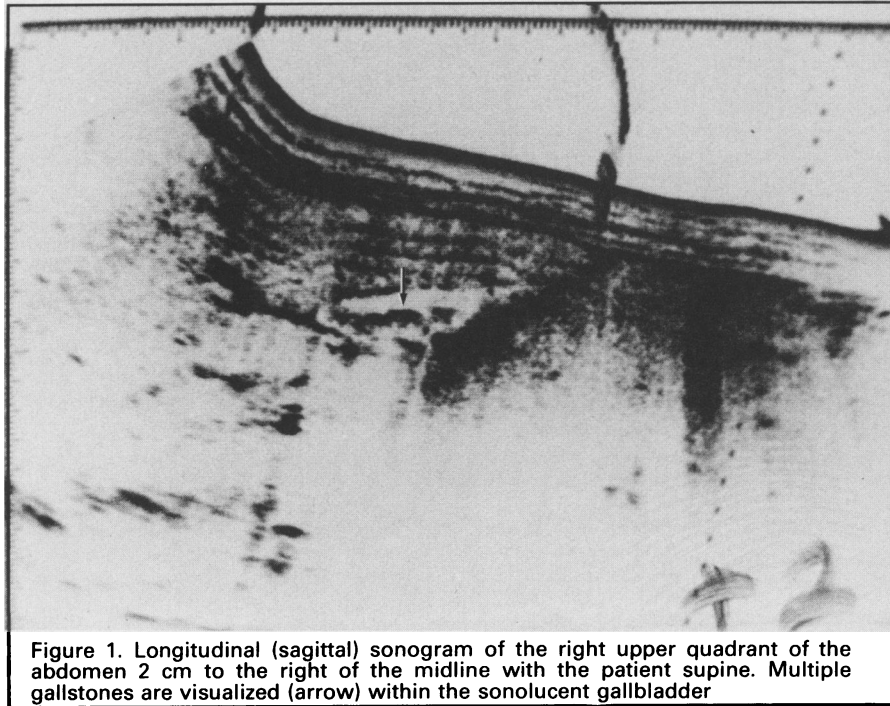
Longitudinal (sagittal) sonogram of the right upper quadrant of the abdomen 2 cm to the right of the midline with the patient supine. Multiple gallstones are visualized (arrow) within the sonolucent gallbladder
